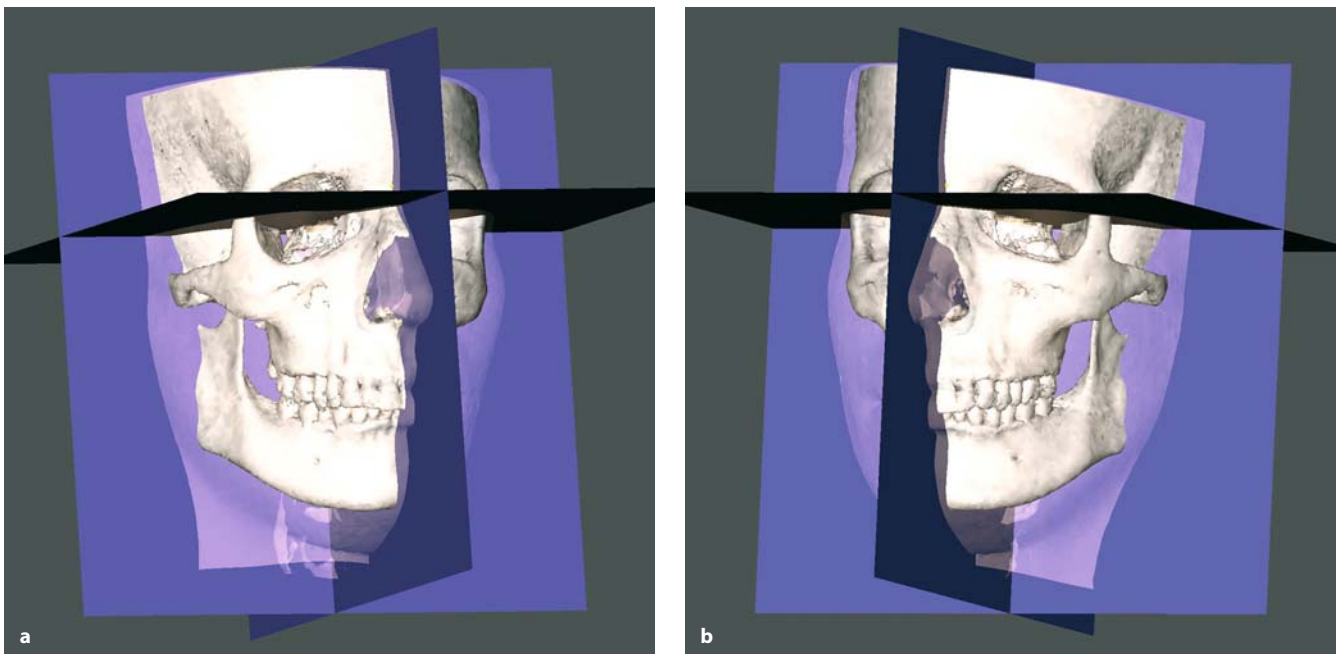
a, b. 3-D cephalometric reference system superimposed on the hard and transparent soft tissue surface representations (3-D CT, patient K.C.)
